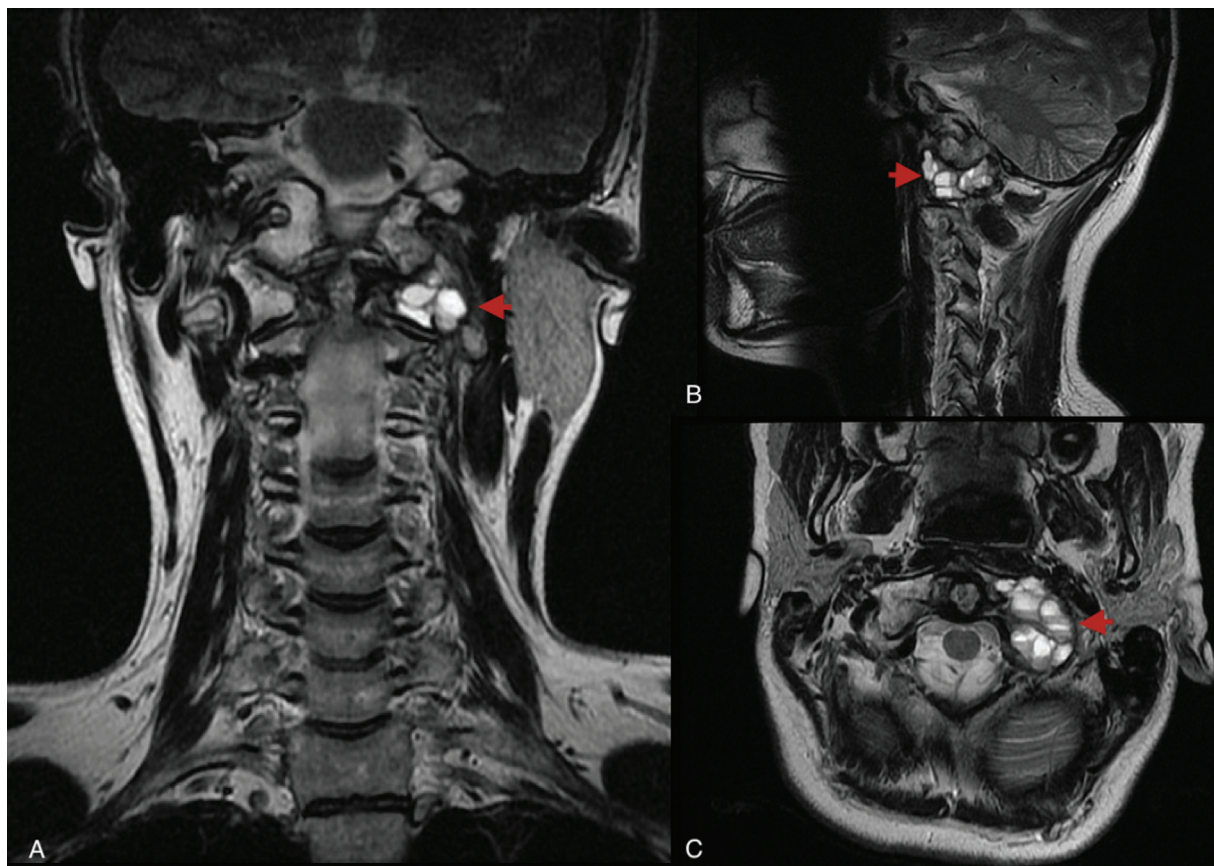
Cervical T2-weighted magnetic resonance imaging scan with contrast medium. Coronal (A), sagittal (B), and axial (C) sections showing a lesion measuring $28 \times 15 \times 21$ mm in the left lateral mass of the atlas, filled with multiple fluid-fluid levels.
